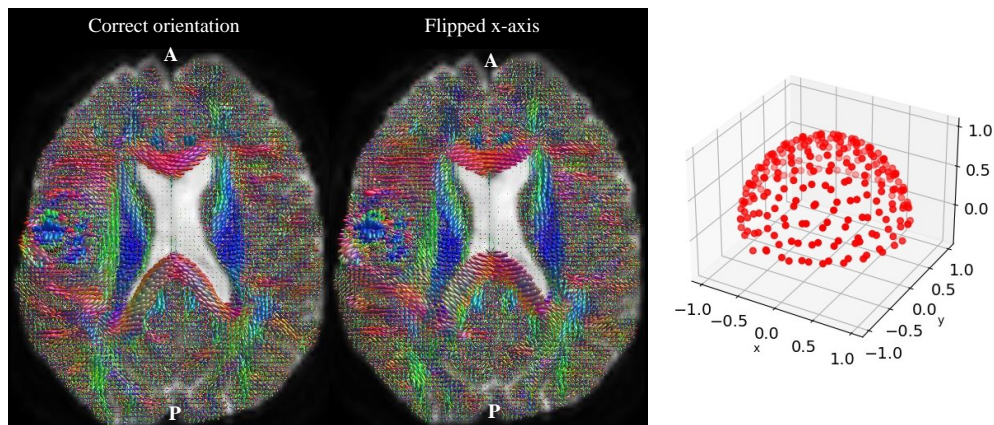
Left:* Demonstration of the effect of flipped diffusion gradient axis on the FOD lobe orientation overlaid on a b_0 diffusion volume. The correct orientation of FOD lobes follows the anatomical curvature of the genu and splenium of the corpus callosum, while flipping the x-axis of the gradient vectors causes the FOD lobes to shift away from the nerve fiber orientation. Color-coding of FOD lobes: blue – inferior-superior, red – medial-lateral, green – anterior-posterior. *Right:* Example DWI data acquisition scheme with uniform distribution of diffusion gradients on half a sphere. Abbreviations: A = anterior, P = posterior.
